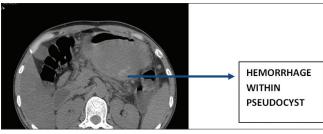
Non-enhanced computed tomography showing high attenuation areas within pseudocyst suggesting hemorrhage
